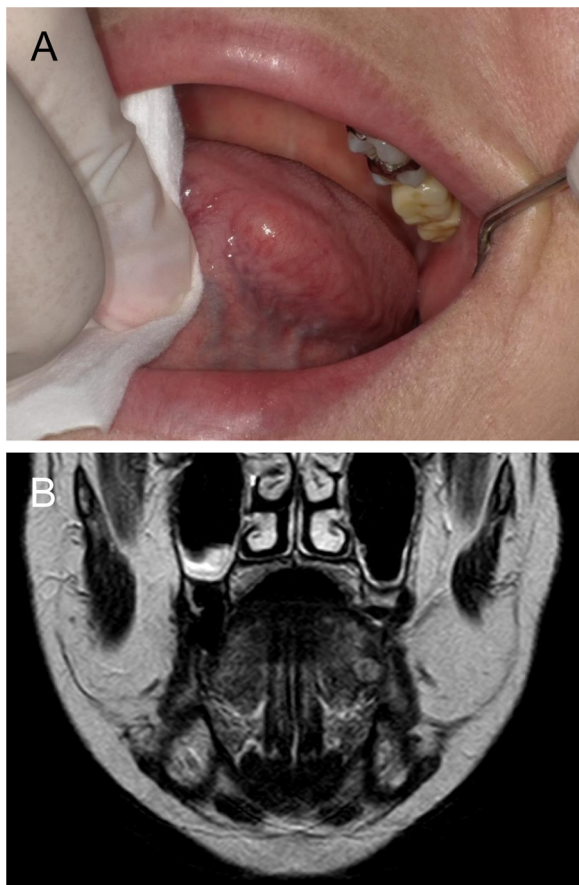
Clinical and radiological findings of the tumour. (A) Intraoral image of the tumour on the left tongue margin. The submucosal mass measured approximately 20×10 mm in size. (B) Coronal T2-weighted magnetic resonance imaging showing a well-defined heterogeneous hyperintensity on the left tongue margin.
